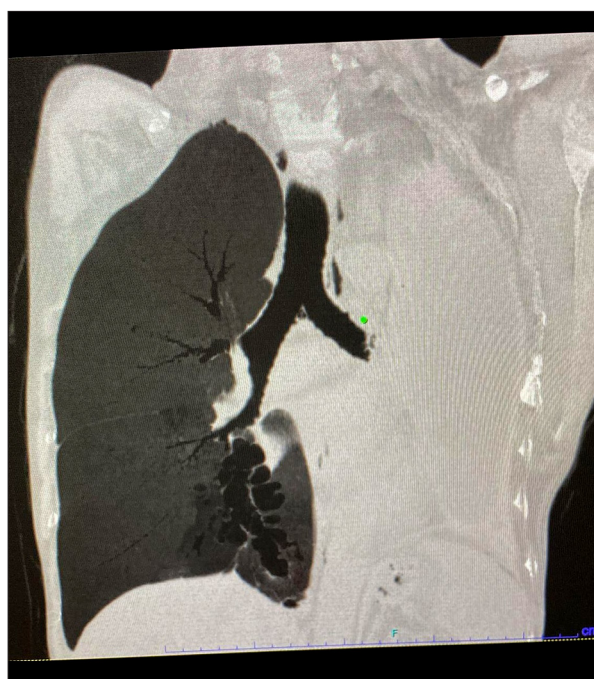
Preoperative thoracic computed tomography showing leftward mediastinal shift after pneumonectomy and bronchiectatic changes in the remaining right lung.
